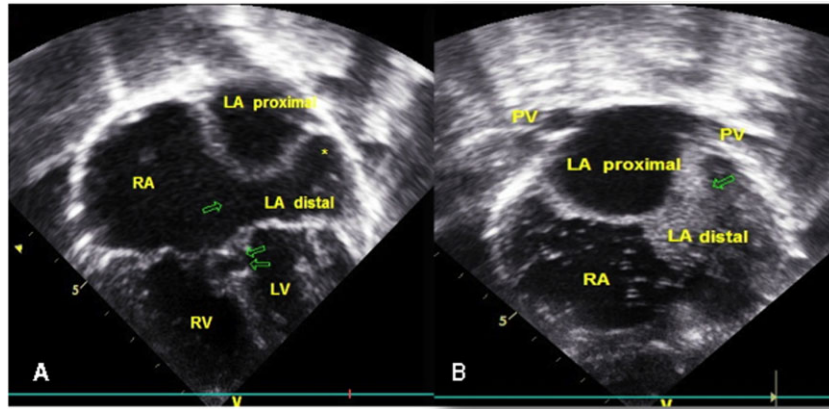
(A) Transthoracic echocardiography showing fibromuscular membrane that divides the left atrium into proximal and distal chambers, primum atrial septal defect (arrow), inlet ventriculoseptal defect (double arrow), and unroofed coronary sinus (*). (B) Contrast-agitated saline injection into the left antecubital vein opacifies the LA before the RA on echocardiographic image in subcostal view. RA, right atrium; RV, right ventricle; LA, left atrium; LV, left ventricle; PV, pulmonary vein.
